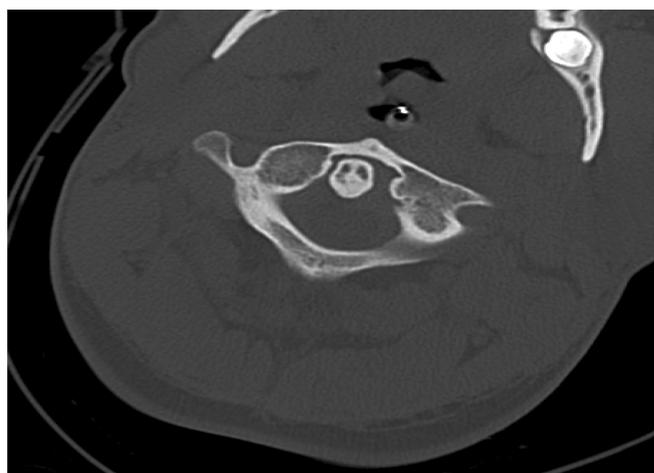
CT coronal view of C1 and C2 in patient with missed C-spine injury.
